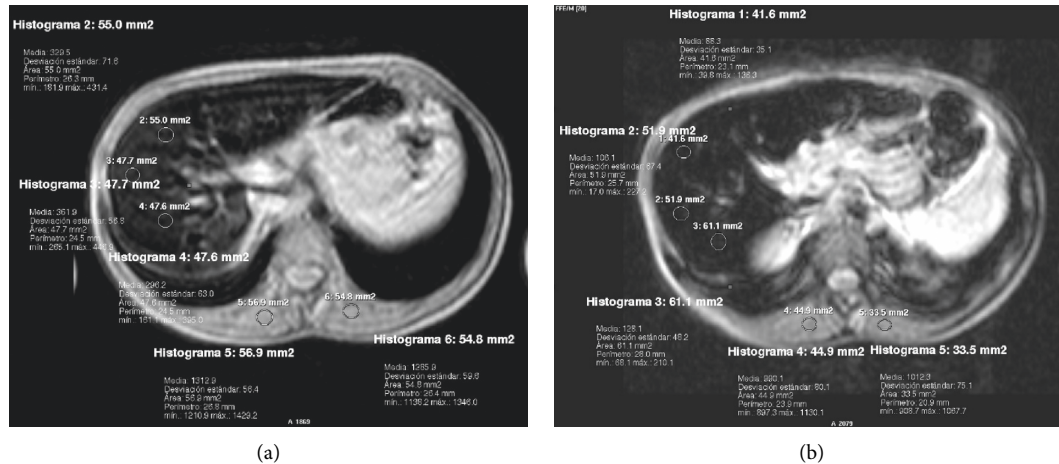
Abdominal MRI of patient. (a) Proton density fast field echo (PD FFE) sequence and (b) relaxation time T2 FFE sequence in the same axial section, with 3 regions of interest (ROI) in the liver and 2 ROIs in the paravertebral musculature to perform.
